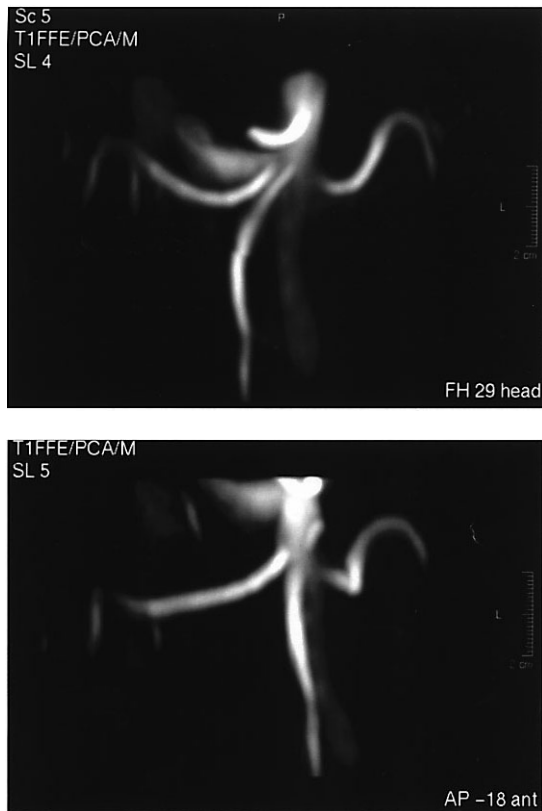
Angio-MRI study of abdominal vessels.
